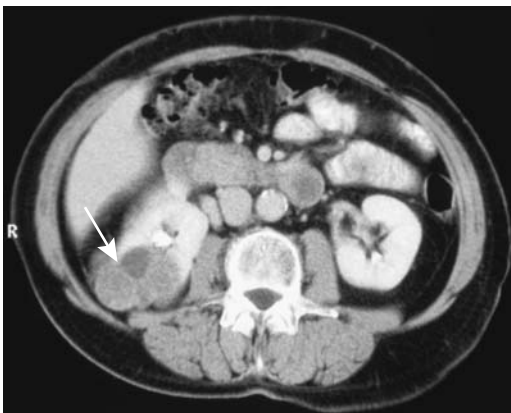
Right renal cell carcinoma. Computed tomography identifies a poorly enhancing tumor (arrow). (Courtesy of Algidas Basevicius, M.D., Kaunas Medical University, Kaunas, Lithuania.)
